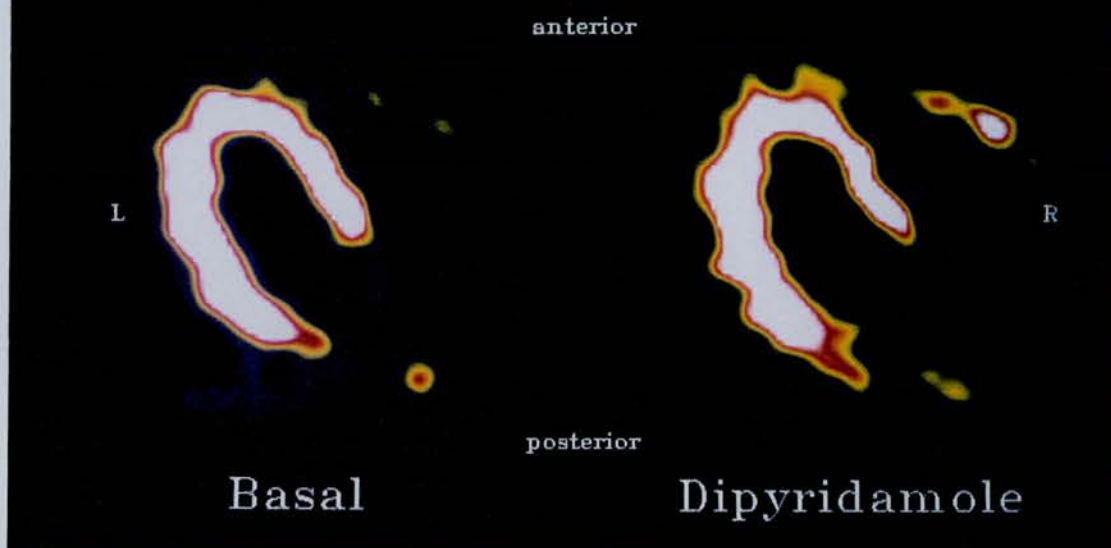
Upper panel) Myocardial washout images derived from $C^{15}O_2$ inhalation at basal and during dipyridamole stress at a mid-ventricular plane. Lower panel) FDG images over 8 planes from apex (upper left image) to base (lower right image) of the heart in a normal subject.
